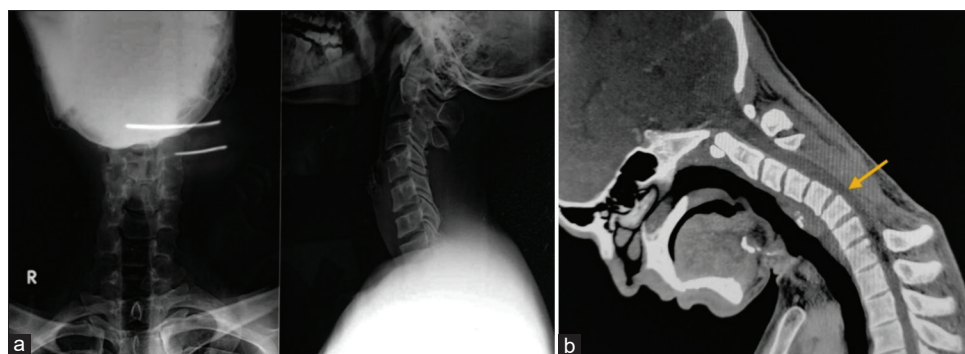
(a) Postoperative X-ray of a patient after 1 year with no significant instability. (b) Postoperative computed tomography venogram with neck flexion with no engorged venous plexus or posterior cord compression (yellow arrow)
